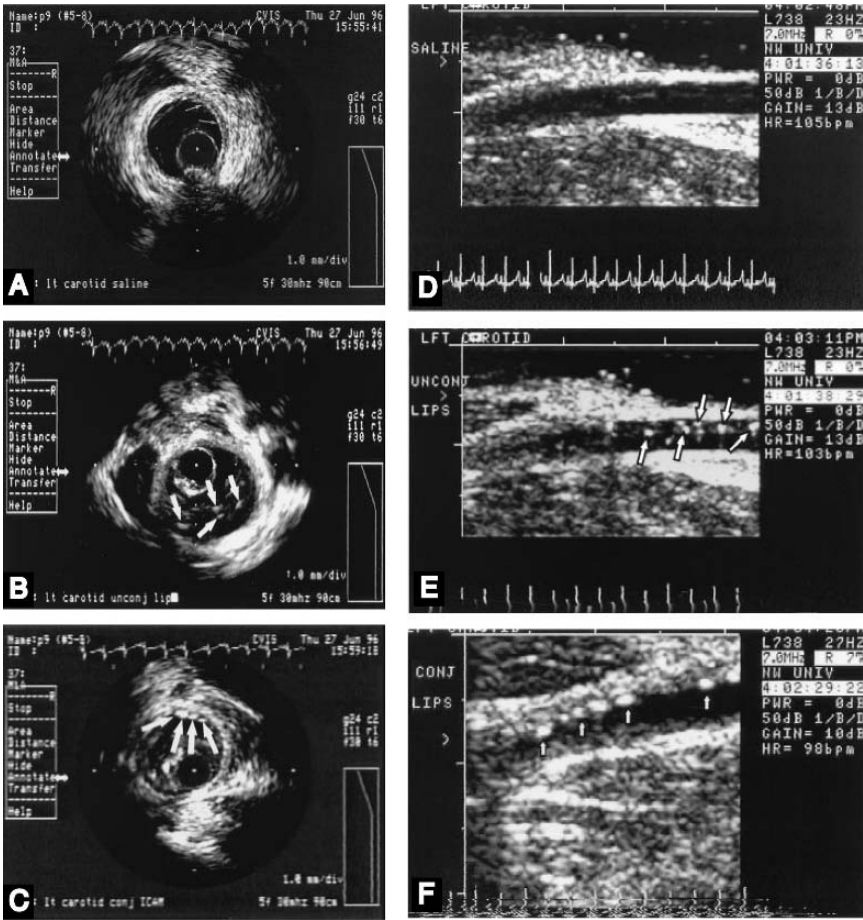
In vivo experiment demonstrating the attachment of anti-ICAM-1-conjugated echogenic immunoliposomes to atherosclerotic arterial wall. Intravascular ultrasound imaging of the atherosclerotic left carotid artery of a Yucatan miniswine (notice the circular atheroma deposition). A After injection of saline (arrows point to early atheroma). B After injection of unconjugated liposomes (arrows point to liposomes within lumen). C After injection of anti-ICAM-1-labeled liposomes (arrows point to liposomes attached to the atherosclerotic plaque). Transvascular ultrasound images of the atherosclerotic left carotid artery of a Yucatan miniswine. D After injection of saline. E After injection of unconjugated liposomes (arrows point to liposomes within the lumen). F After injection of anti-ICAM-1-labeled liposomes (arrows point to liposomes attached to the atherosclerotic plaque). Reproduced with permission from Demos et al. (1999).
